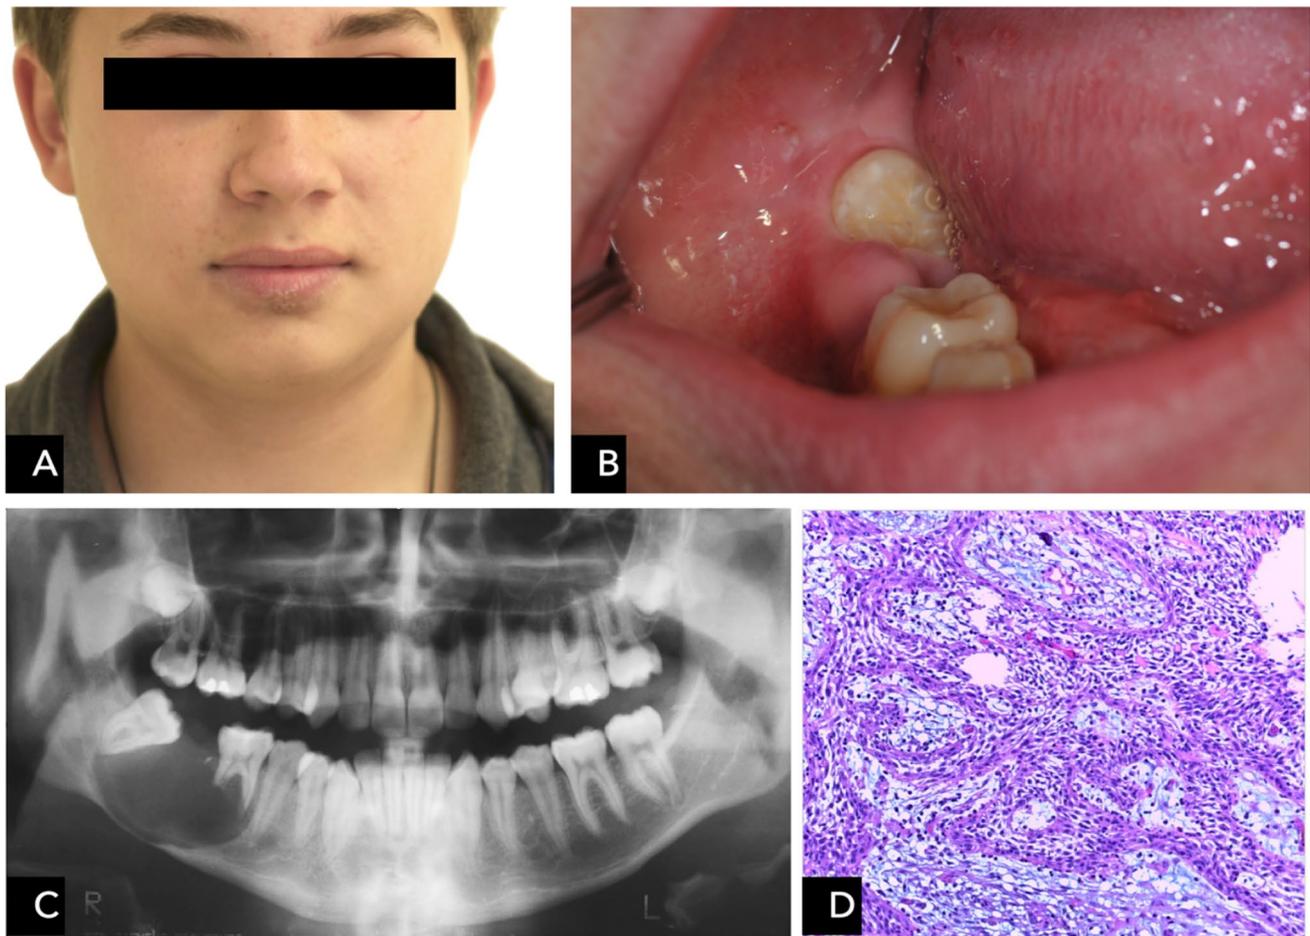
a Frontal image showing slight right facial asymmetry. b Intraoral image showing mesioangulated semi-erupted tooth 4.8 with an irregular mesial edentulous area. c Panoramic radiography showing a radiolucent area in the right mandibular body with defined
